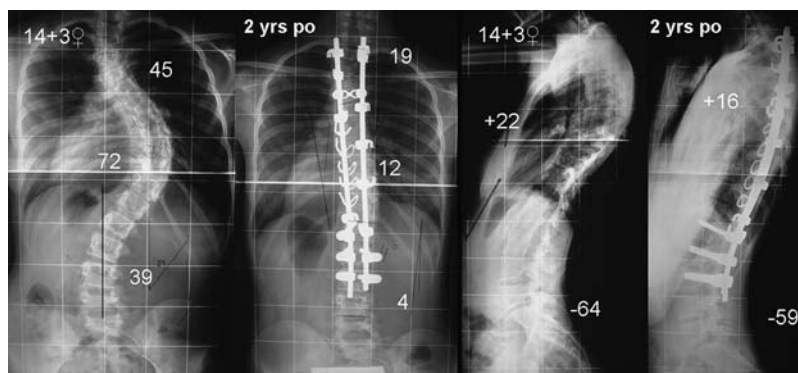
The patient underwent a posterior spinal fusion (T2–L3) with a wide posterior release and a hybrid sublaminar-wire construct. Postoperative radiographs showing 83% of correction.
